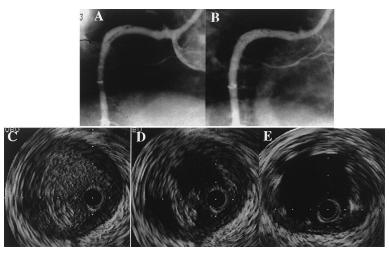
A representative case in which the negative contrast images influenced additional treatment. A, coronary angiogram after directional atherectomy revealed a dissection at the proximal right coronary artery; B, a plain intravascular ultrasound image demonstrated the wide lumen with a suspect of intimal flap at 6 o'clock; however, it was not clear because of reflections from red blood cells; C, a negative contrast image documented a large bulky flap which straddled the lumen; D, based on these findings, a Wiktor stent was subsequently implanted; E, intravascular ultrasound image after Wiktor stent implantation demonstrated that the flap was completely relieved with stent struts.
